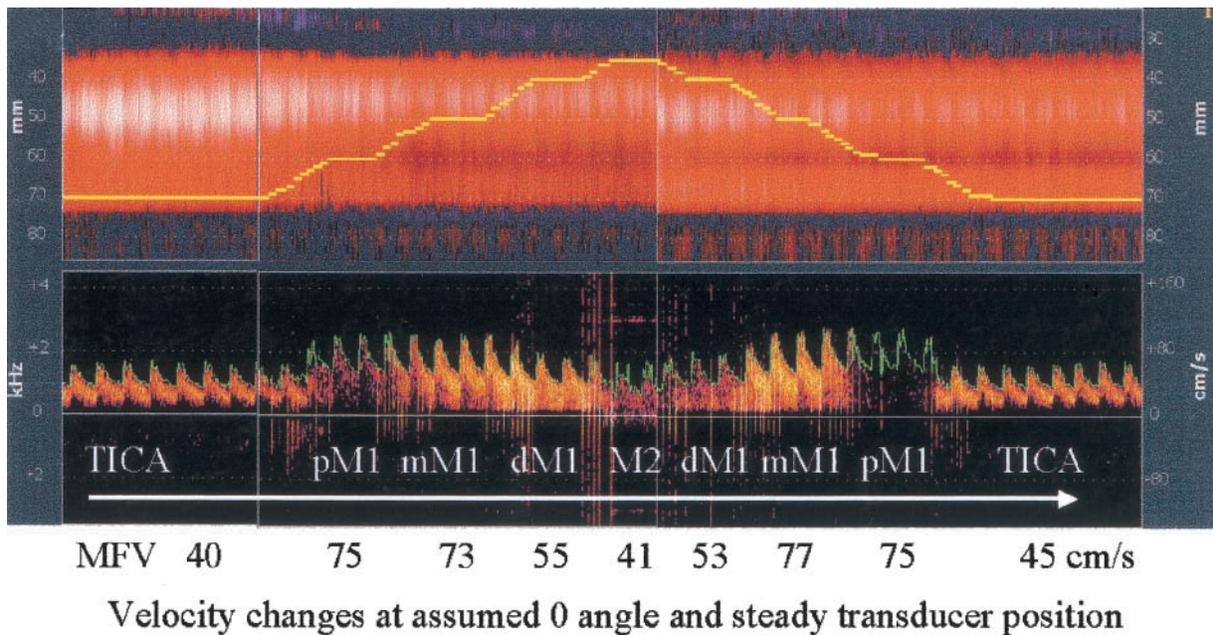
Power motion mode Doppler-guided transcranial Doppler (TCD) velocity measurements. TCD spectra were obtained at an assumed 0° of insonation at a steady transtemporal position of the transducer. The velocity changes in the same plane of insonation help one appreciate the tortuous course of the middle cerebral and other arteries. MFV = mean flow velocity, TICA = terminal internal carotid artery, PM1 = proximal M1, mM1 = mid-M1 segment, dM1 = distal M1 middle cerebral artery segment.
